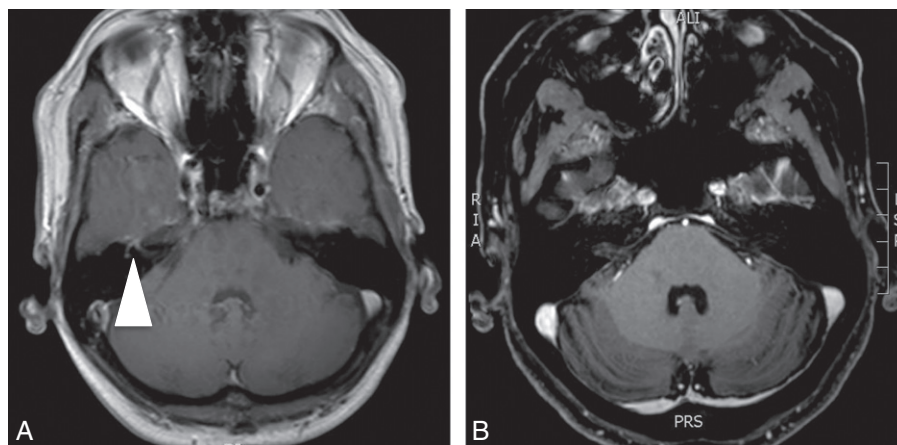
Imaging obtained prior to treatment intervention. (A) Axial MRI with T1-weighted post-contrast demonstrates an enhancing lesion within the right internal auditory canal (arrowhead), with enhancement of the right labyrinthine and tympanic segments of the facial nerve (arrow). (B) Superior axial MRI with T1-weighted post-contrast also shows enhancement and enlargement of the right trigeminal nerve (arrowhead).
